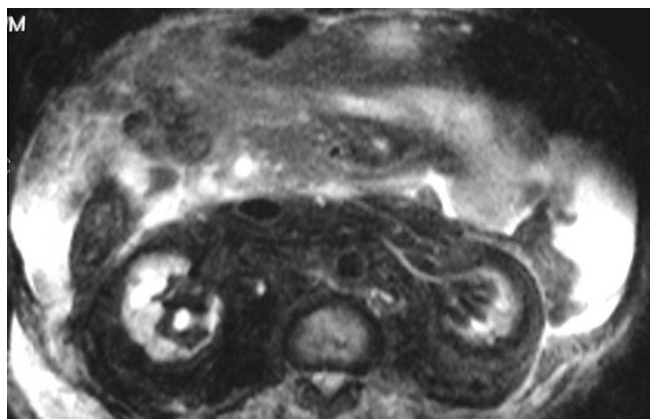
Axial T2-weighted abdominal MRI showing retroperitoneal fibrosis involving the perirenal and para-aortic regions with right hydronephrosis, enlarged renal calices and left kidney atrophy.
